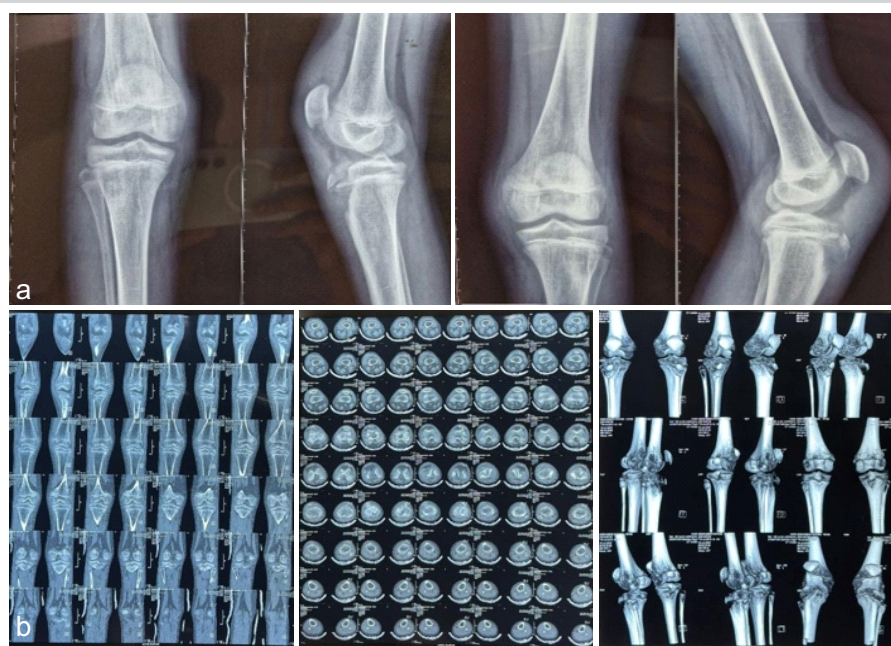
(a) Pre-operative bilateral knee X-rays (anteroposterior and lateral) confirming Type II tibial tuberosity avulsion fractures and patella alta. (b) Pre-operative bilateral knee computed tomography scans (sagittal and coronal reconstructions) detailing fracture displacement and physeal extension.
